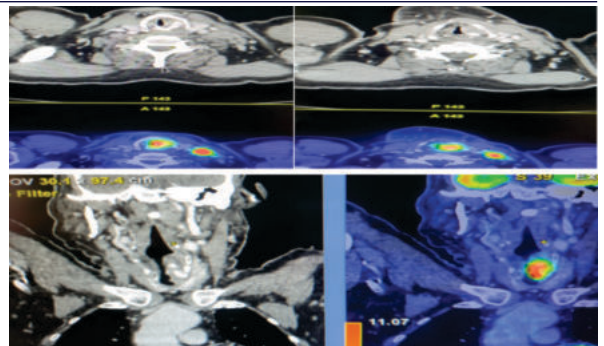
PET CT showing tumor.
